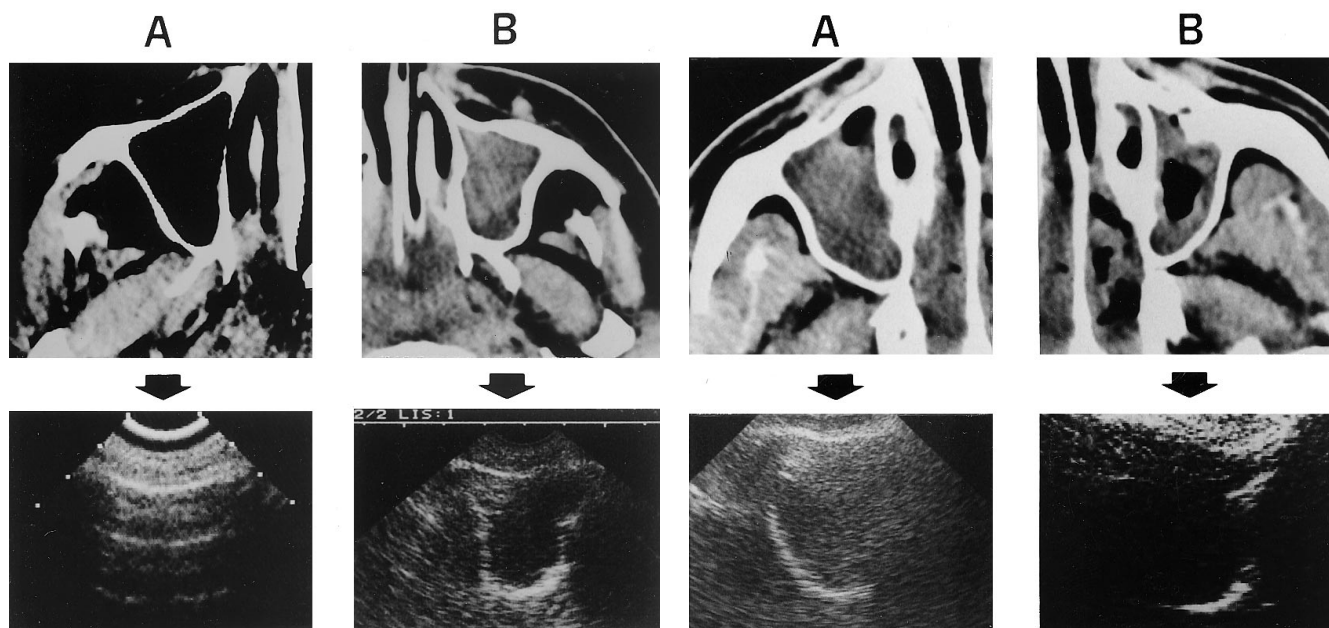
Normal versus pathologic ultrasound pattern. A: normal right maxillary sinus (CT), and ultrasound equivalent, transverse section (arrow): complete acoustic barrier. B: total opacity of the left maxillary sinus (CT), and ultrasound equivalent: the internal, posterior and external walls of the sinus outline the opacified cavity, giving a complete "sinusogram"
